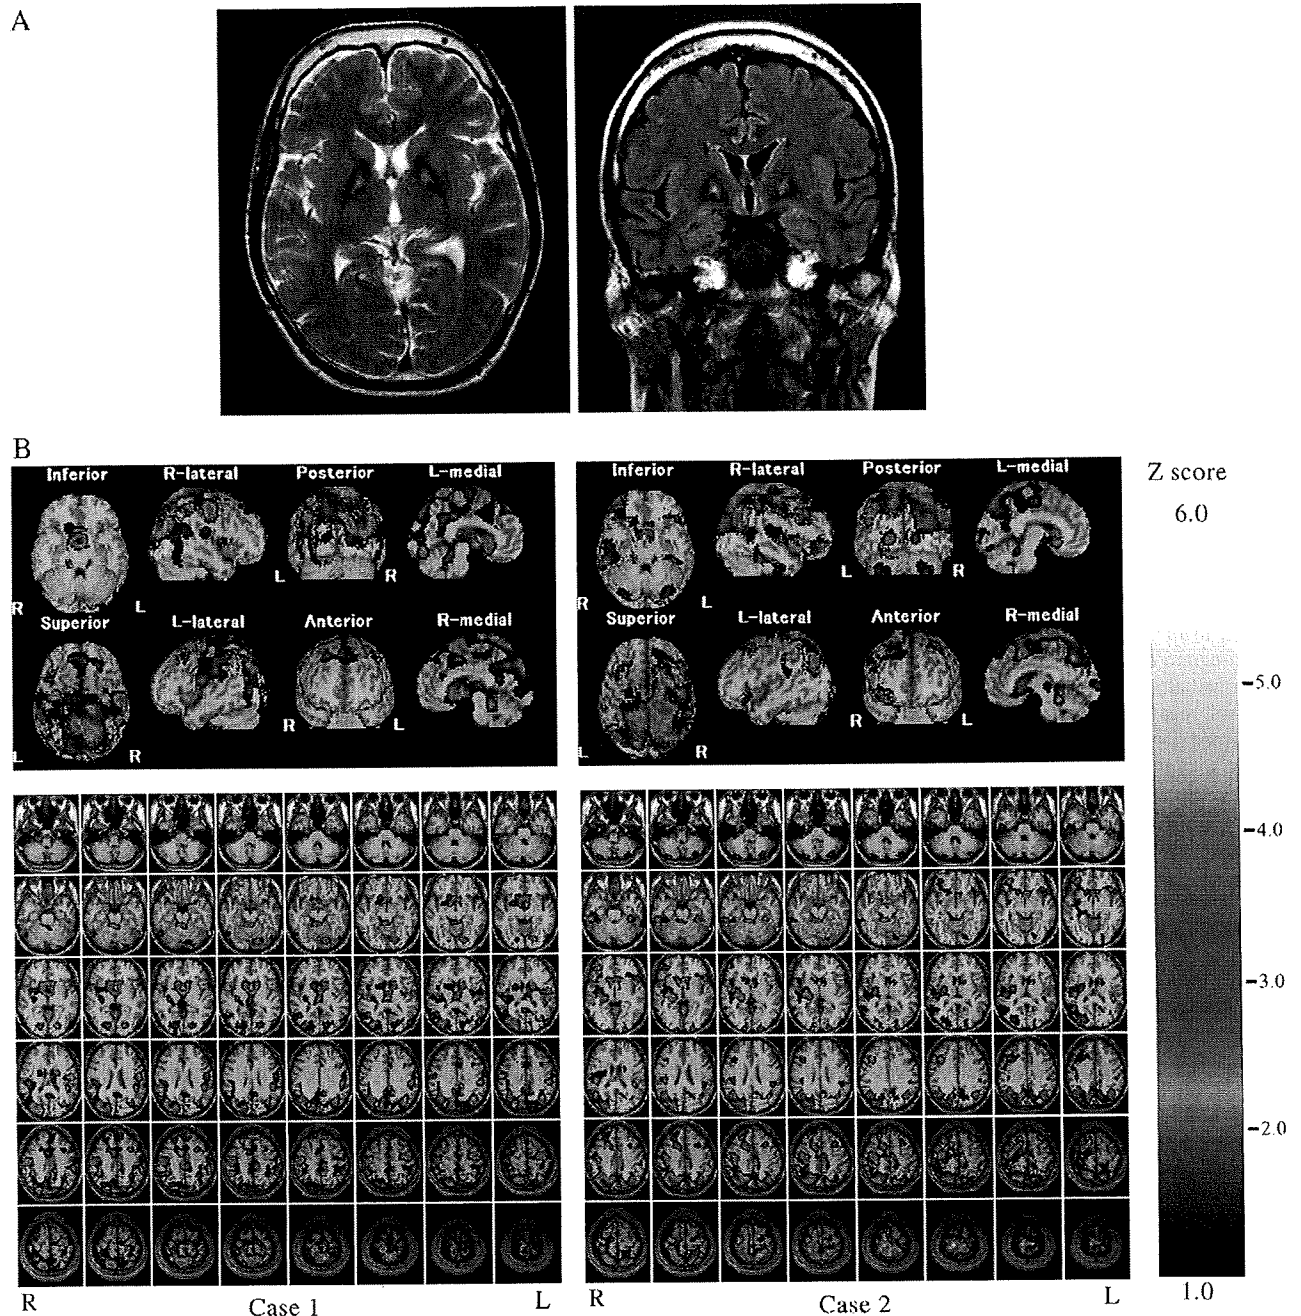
Neuroradiological findings. A. MRI findings in the case 2 patient. An axial section of a T2 weighted image (left) and a coronal section of fluid attenuated inversion recovery image (right) are shown. Note that the MRI shows no brain atrophy. B.  $^{99m}\text{Tc}$ -ECD SPECT in both cases. The Z-score maps displayed on an anatomically standardized MRI template are shown.
